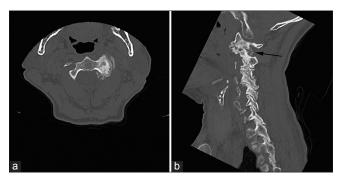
Axial (a) and left paramedian sagittal (b) preoperative computed tomography of the cervical spine. Unilateral arthrosis of the left C1-C2 facet joint is shown with obliteration of the joint space and extensive osteophyte formation. The posterior osteophyte encroaches into the expected site of the left C2 dorsal ramus (black arrow)
